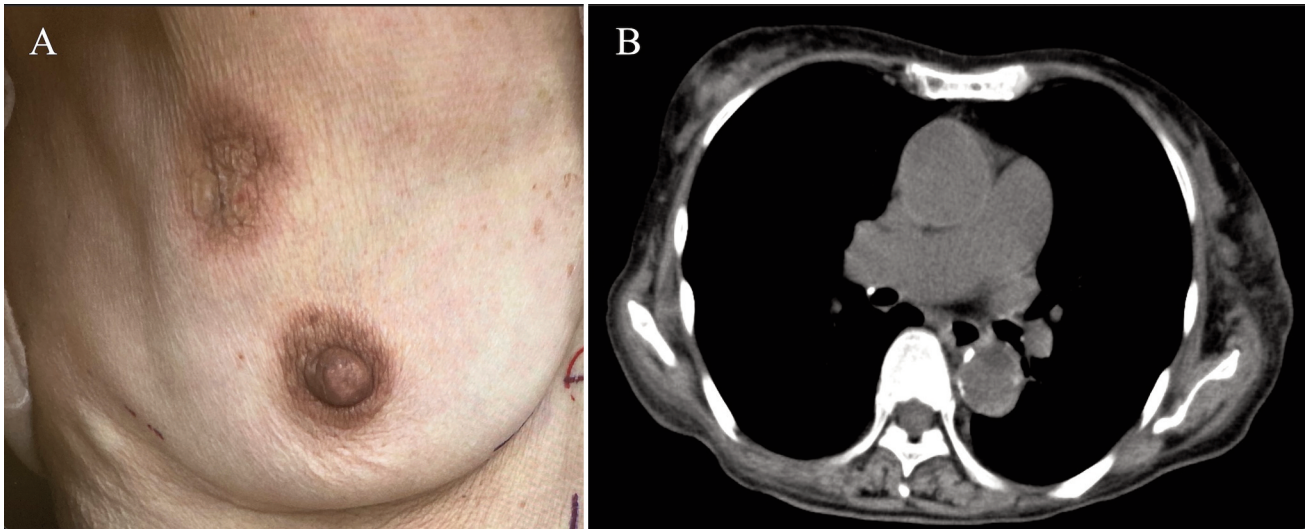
Posttreatment appearance (A) and computed tomography (B) images of the right breast.
